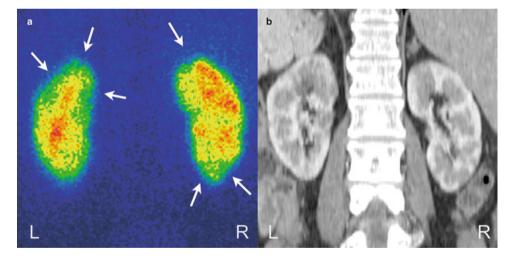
Evaluation of lesions by renal cortex scintigraphy (a). To compare the anterior CT images with the posterior images on scintigraphy, left-right inversion of the former was performed (b)
